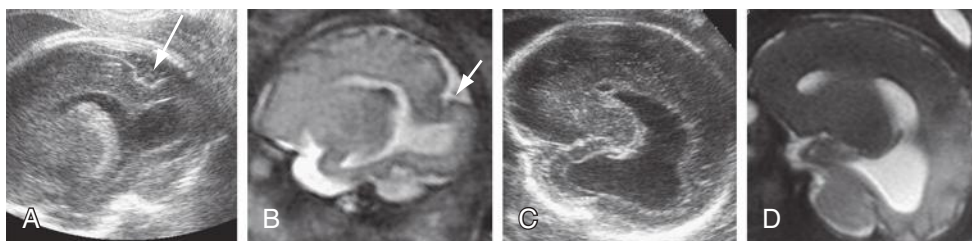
Fetal cortical abnormalities demonstrated by sonography and magnetic resonance imaging. A and B, Abnormal convolution associated with unusual shape of the cortex (*arrows*) and underlying lateral ventricle. C and D, This fetus at 34 weeks' gestation has a very smooth brain and an unusual echogenicity of the cortex.
